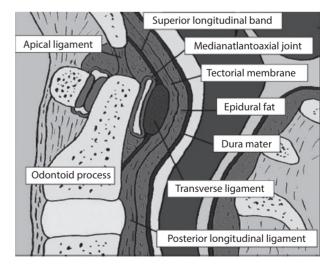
Anatomy around the atlantoaxial joint (Reproduced with permission from: Tojo S, *et al.* Factors influencing on retro-odontoid soft-tissue thickness: analysis by magnetic resonance imaging. *Spine* 2013; 38: 401–6.)
